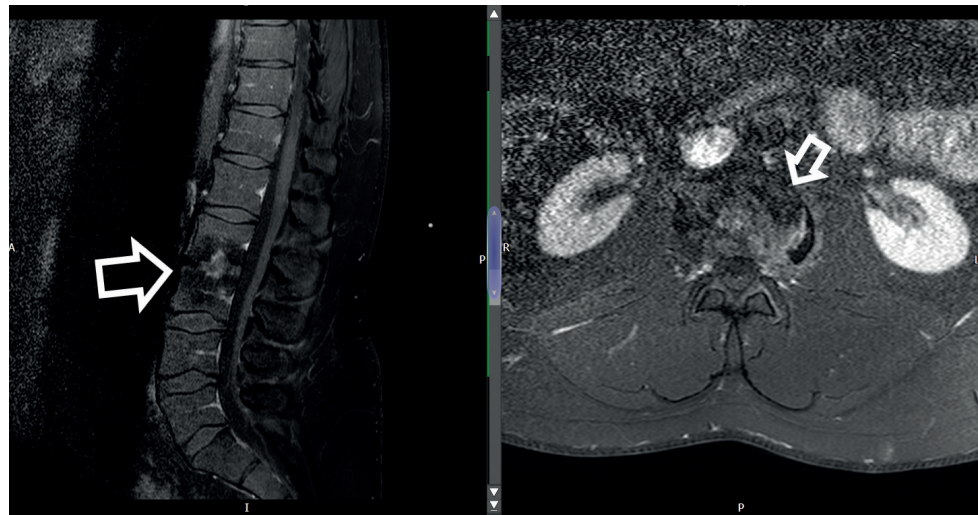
T1-weighted magnetic resonance imaging showing (a) a sagittal view of the lumbar spine with low signal uptake in the end plates of L2 and L3 with early destructive changes of the L2 vertebrae. b. An axial view taken at the L2–L3 level shows low signal within the intervertebral disc.
